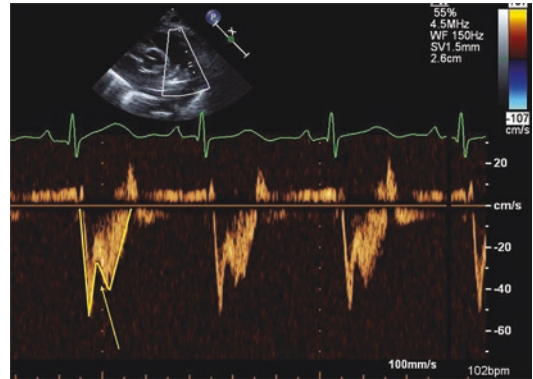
Pulmonary doppler demonstrating Flying “W” sign (outlined in yellow) with a pulmonary mid-systolic notch (arrow), consistent with elevated pulmonary vascular resistance and decreased vascular compliance
